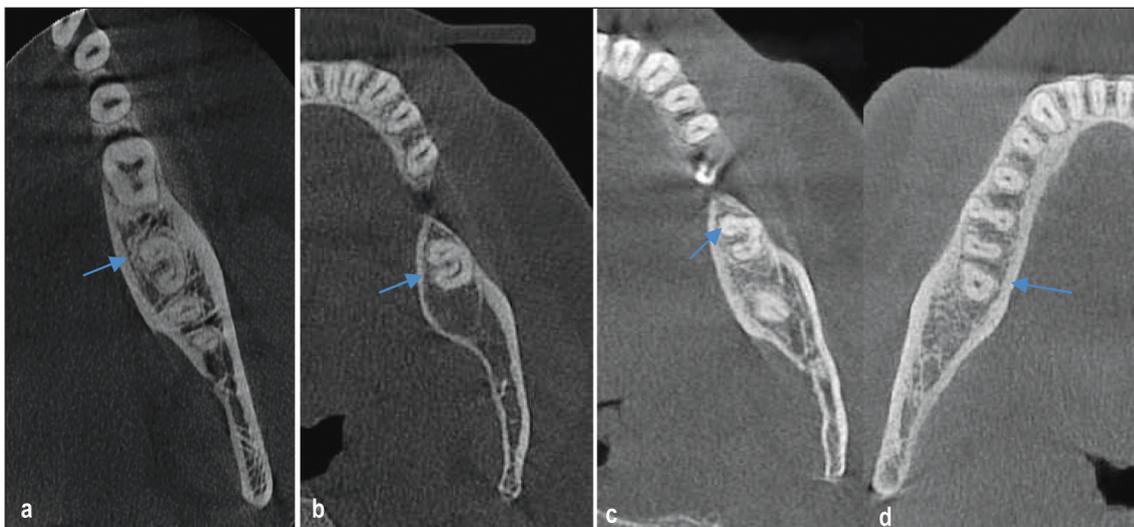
C-shaped canal configuration classifications in axial slices of cone beam computed tomography images; a) Type of C1 b) Type of C2 c) Type of C3 d) Type of C4.
